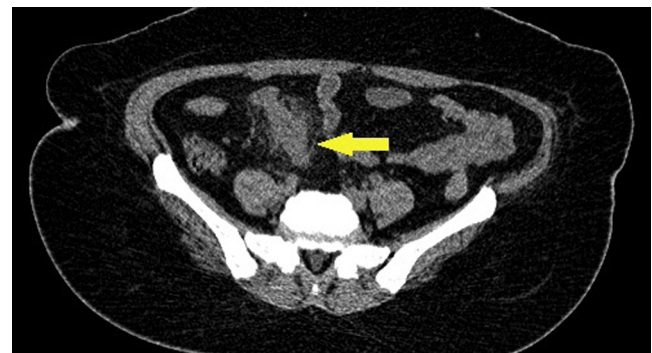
Thirty-four year old female patient with right sided abdominal pain and dysuria. CT stone protocol revealed an oblong tubular structure related to the ileal loops, with stranded adjacent fascial planes, proven at surgery to be an inflamed Meckel's diverticulum.
